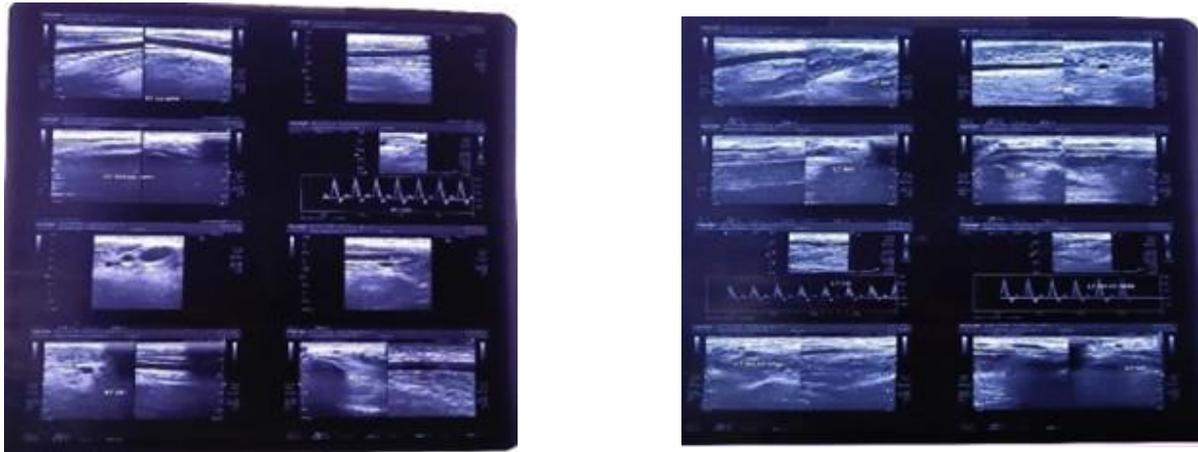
Preoperative Vascular Mapping with Doppler Ultrasound
